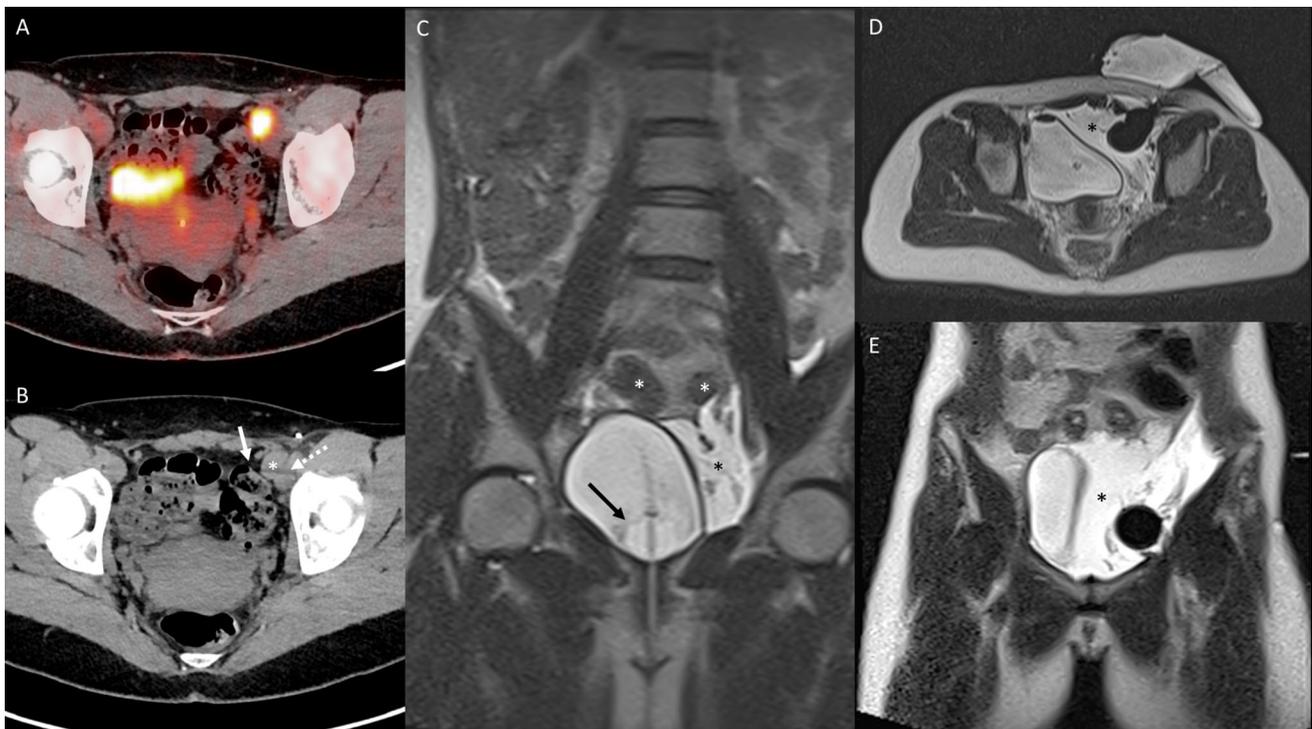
MRI-guided cryoablation of a single iliac lymph node metastasis from melanoma. A Axial PET-CT shows an FDG avid left external iliac lymph node. B The lesion (asterisk) is in close vicinity to the colon (arrow) and external iliac vessels (dotted arrow). C A double-lumen bladder catheter (black arrow) is inserted and the bladder is filled with 1L of saline, thereby displacing the bowel (white
